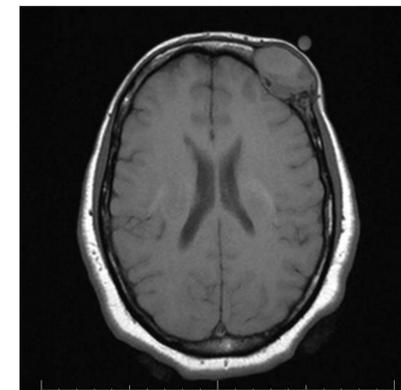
Axial T1 brain MRI without gadolinium demonstrating a diploic space lesion with expansion of the inner and outer tables of the skull
